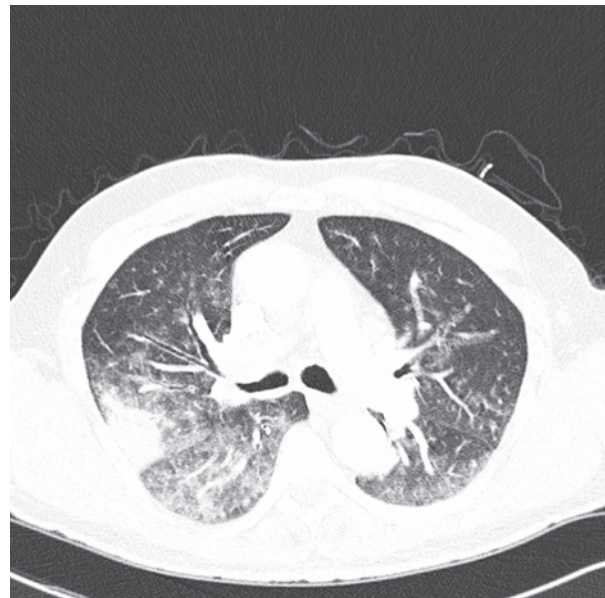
Chest computed tomography image of right upper lobe mass, ground glass infiltrates, and left hilar lymphadenopathy
